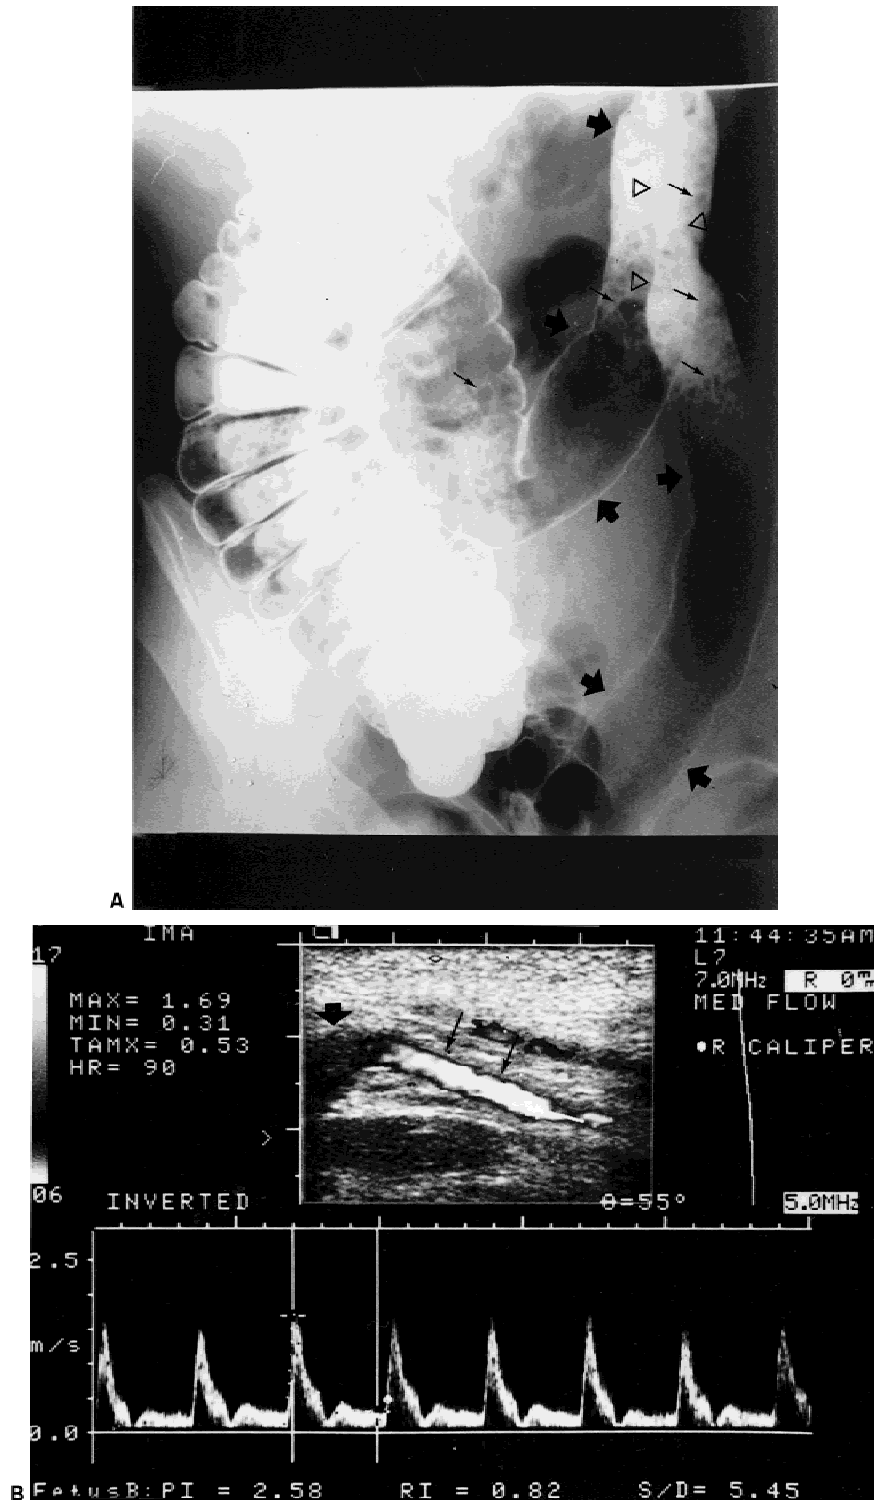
Forty-year-old woman with active ulcerative colitis. (A) Double-contrast barium enema x-ray study shows narrowing of the proximal descending colon and splenic flexure (arrowheads) and loss of haustral folds in the descending and transverse colon (wide arrows). Extensive acute ulceration with hyperplastic polyp-like mucosa (thin arrows) is visible in the descending and transverse colon. (B) Duplex sonogram of the inferior mesenteric artery (IMA) (thin arrows) shows loss of triphasic spectral pattern and increased peak systolic velocity, end-diastolic velocity, and mean velocity. Wide arrow, aorta. (C) Duplex sonogram of the superior mesenteric artery (SMA) also shows a loss of triphasic spectral pattern and increased peak systolic velocity, end-diastolic velocity, and mean velocity. Velocities in the IMA are greater than those in the SMA. Arrowheads, SMA; arrows, aorta.
